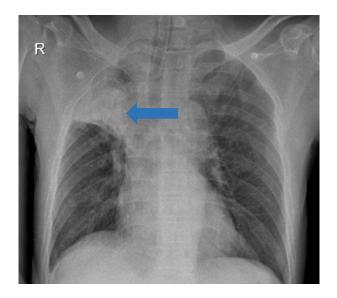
Chest radiograph 7 months prior to the current admission showing an opacity in right upper zone (arrow)
